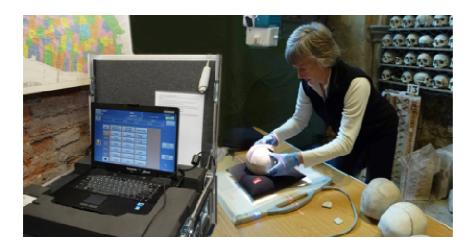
Portable Direct Digital Radiography (DDR) equipment. The portability enables easy and fast set up with instant access to radiographic images on screen and an ability to see any pathological changes occurring inside the bones. (Hythe Crypt, Reveal Imaging).
